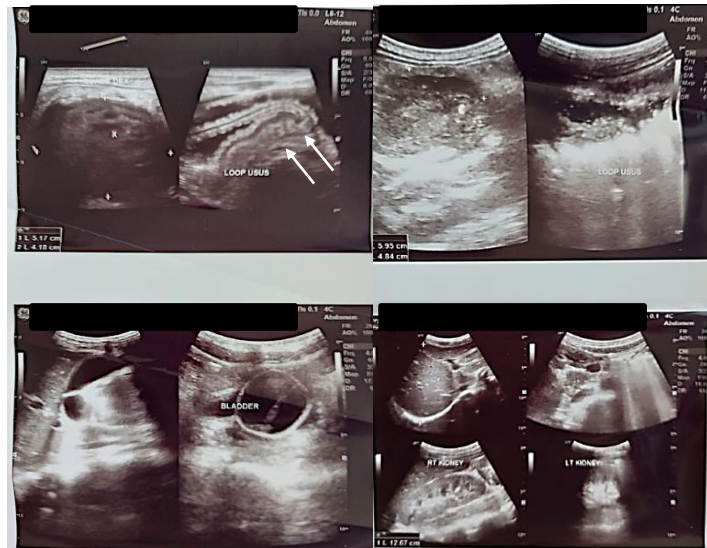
The result of the abdominal Ultrasound of the patient.
